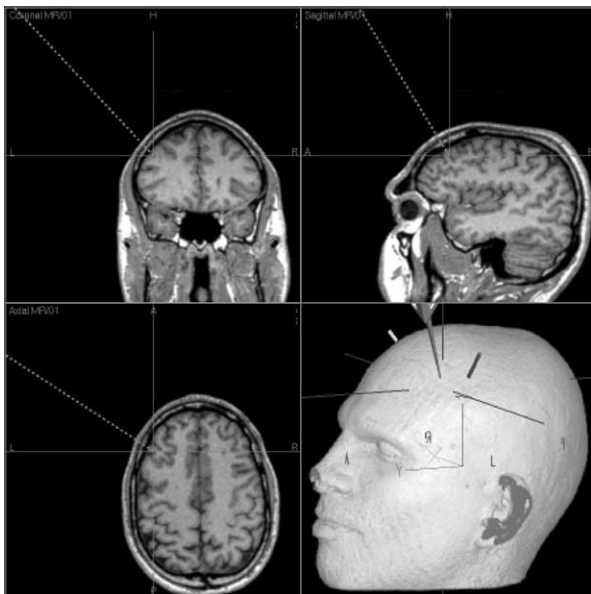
Real time visualization with the Surgical Tool Navigator during the stimulation in the three axes and a 3D-surface rendered MR image of the head. The dotted line represents a line perpendicular through the center of the coil prolonged by about 2 cm towards the cortex, where the peak of the magnetic field is estimated. The magnetic coil was guided to the dorsolateral prefrontal cortex.
